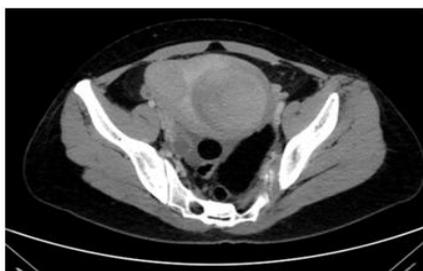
Axial CT scan of pelvic shows bulky uterus with two intramural fibroid (9x7.5cm) with heterogeneous enhancement
